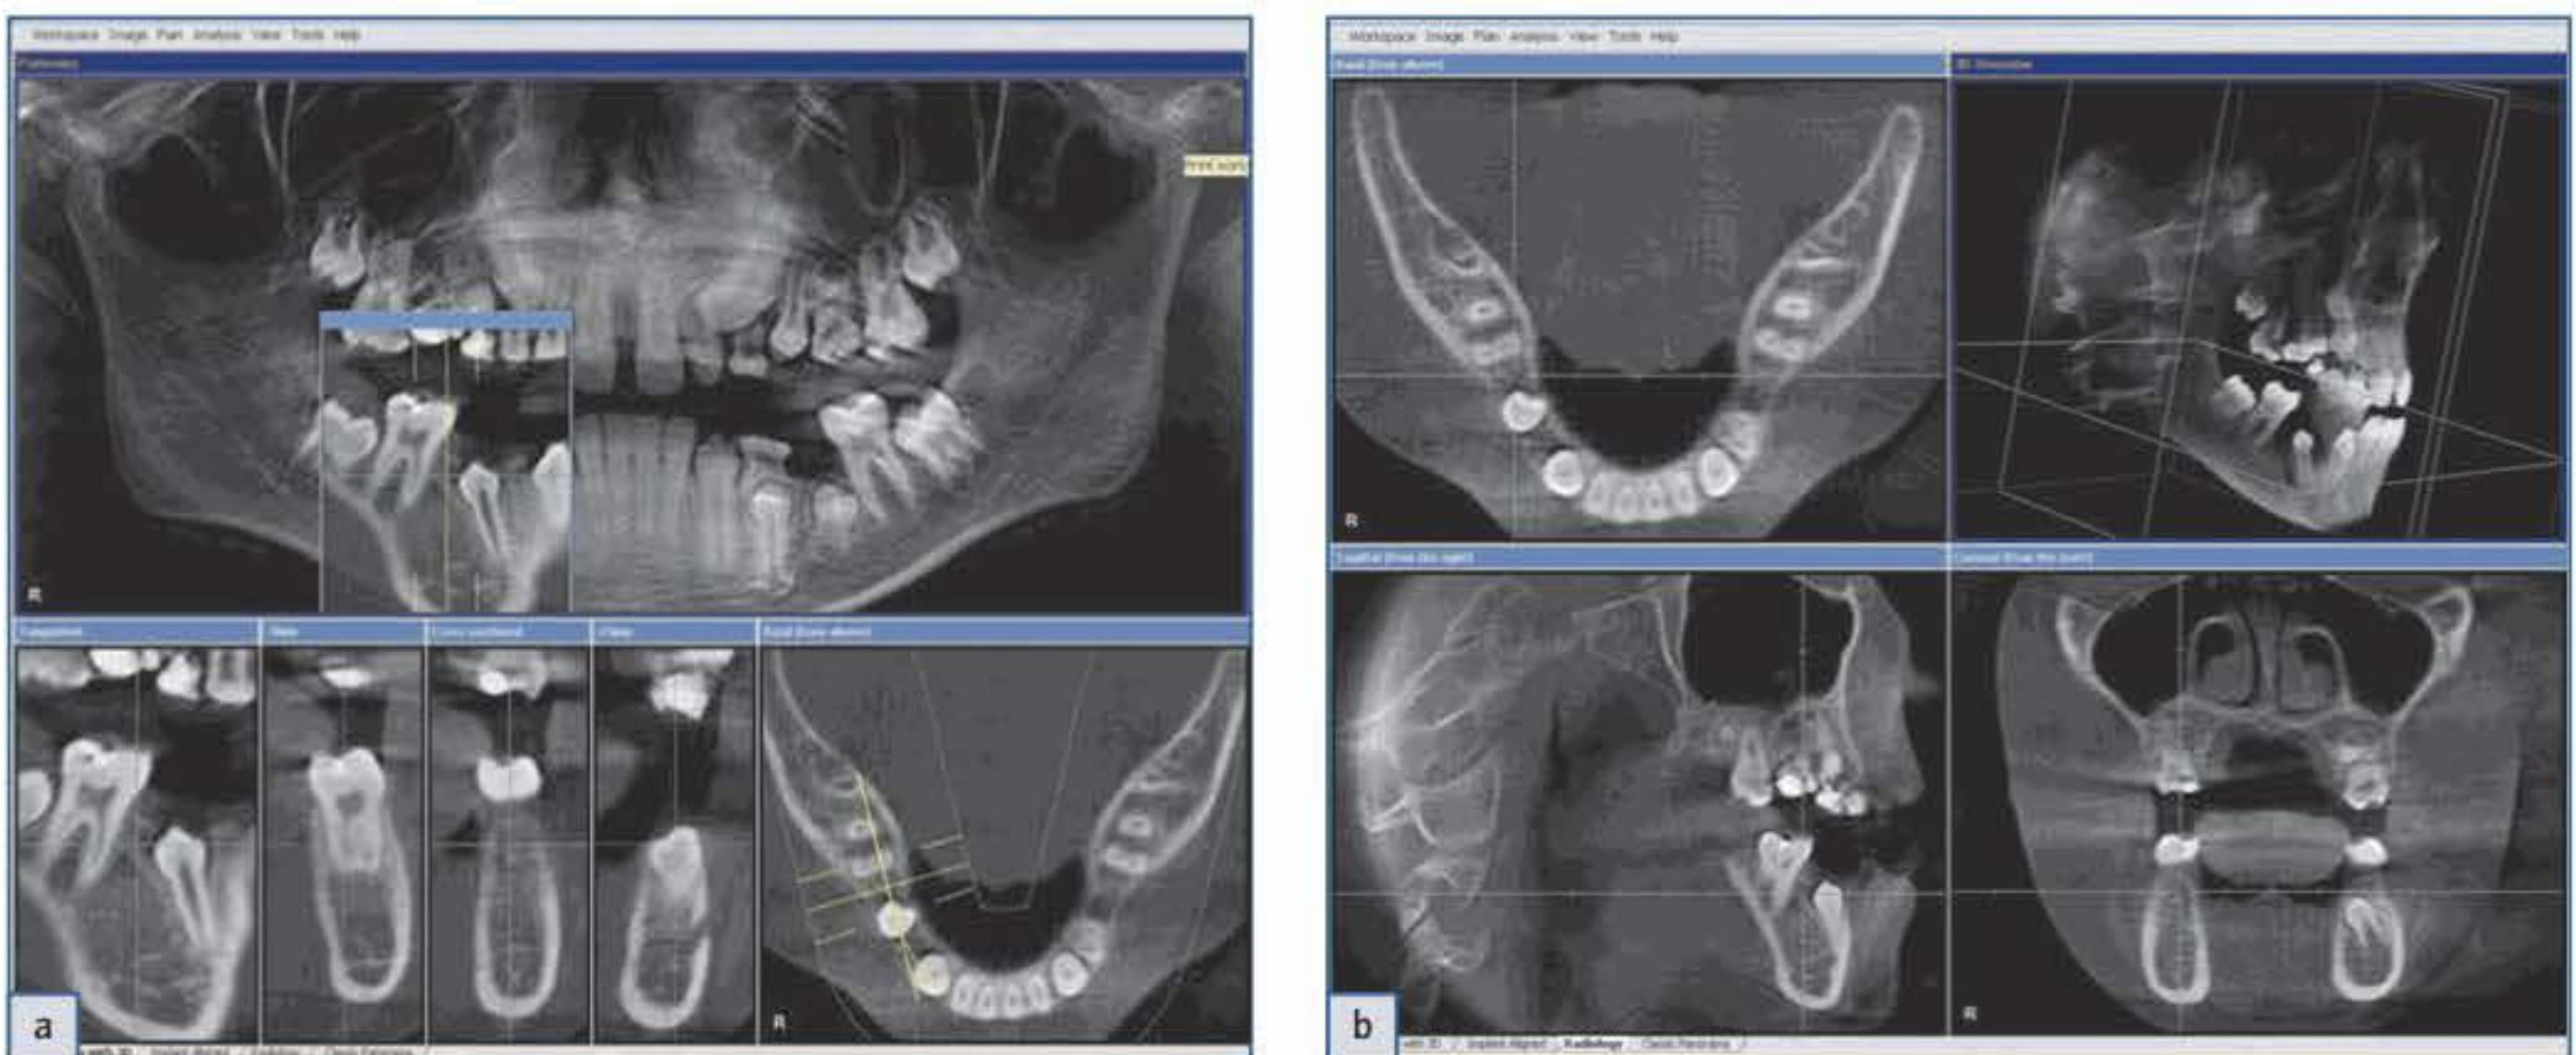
A 10-year-old girl with hereditary history and agenesis of teeth 15 and 45. (a) The cone-beam image demonstrates the agenesis of 15 and 45 as well as delayed mineralization of tooth germs 25 and 35. In addition, 13 and 23 are dislocated. (b) In the axial and transverse image slices for the same patient, a distal migration of the crown of tooth germ 44 can be seen following the loss of tooth 85.
